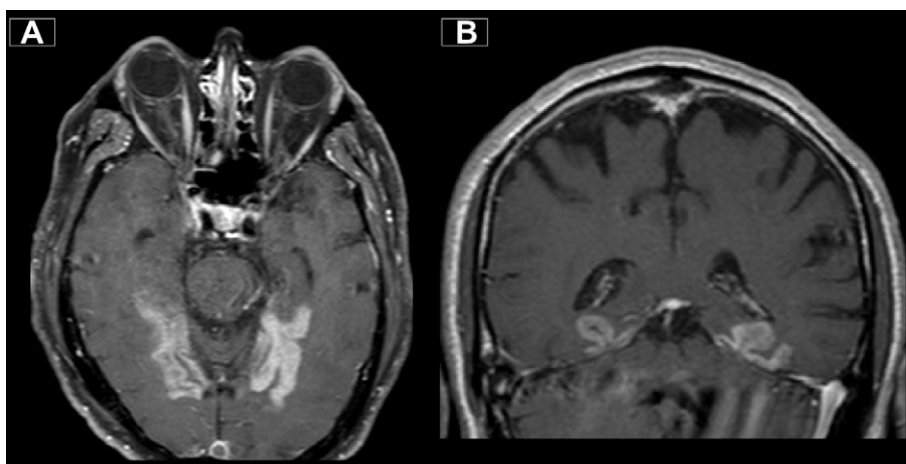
Trasversal (A) and coronal (B) MRI sections of MR lesion. The lesion involves the parahippocampal and fusiform gyri bilaterally and slightly asymmetrically (left > right). Calcarine cortex and temporal poles are bilaterally spared.
